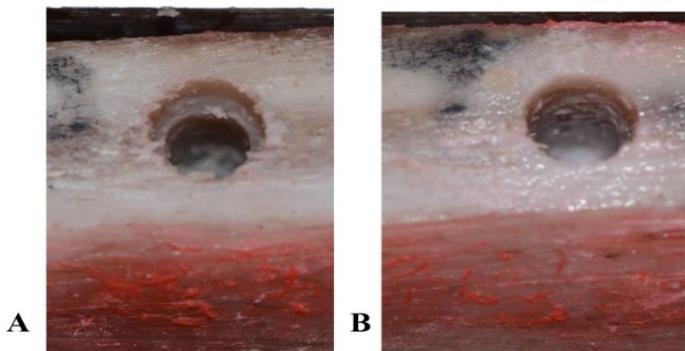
The difference between (A) CD and (B) CT osteotomies (marked D and T respectively).
